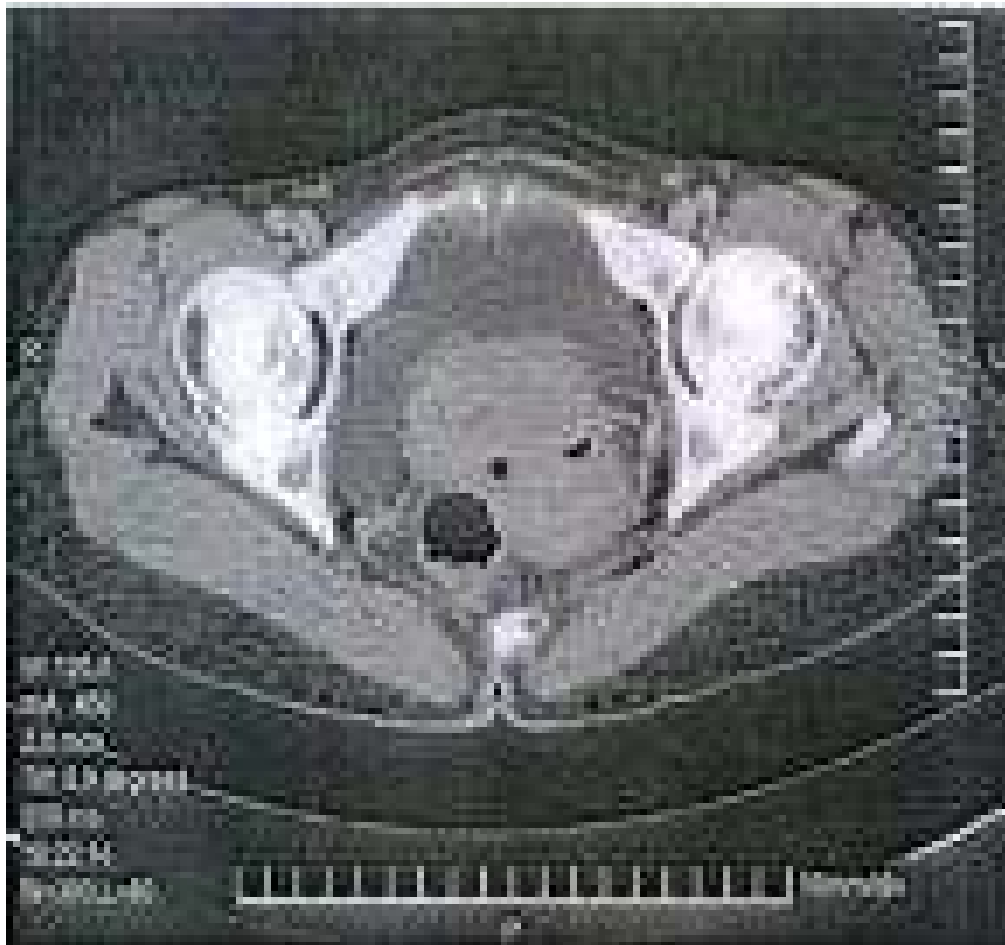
Contrast enhanced CT showing growth in the anterior vaginal wall
